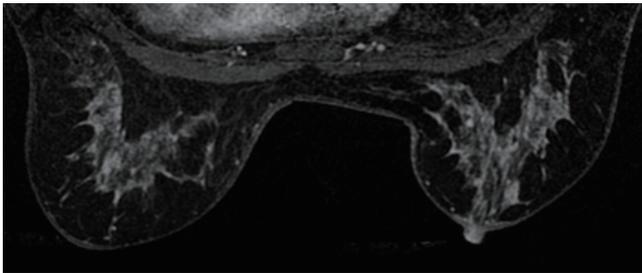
Multiple regions Multiple patchy areas of NMLE in both breasts, and MG shows no calcification. It is interpreted as BI-RADS MRI category 3. Follow-up is recommended. No segmental distribution is found on coronal view. 860052.
